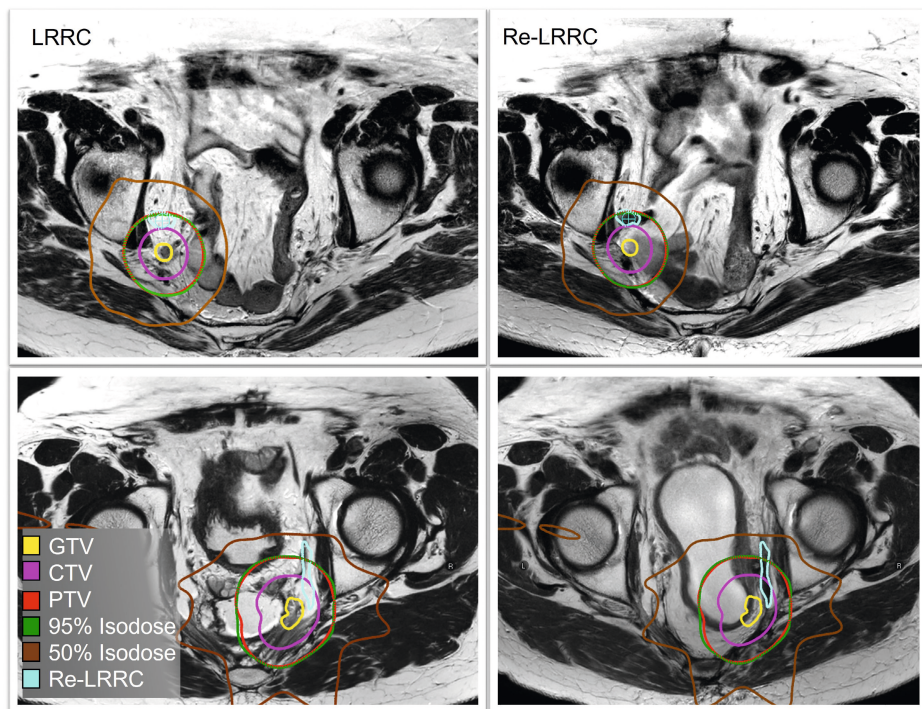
First (left) and second recurrence (right) shown on MRI of two individual cases (above and below). First and second recurrence MRIs have been matched to the LRRC planning CT, to be able to visualise the recurrence in the anatomy of the re-recurrence, and vice versa. The re-recurrence is shown in light blue. LRRC with target volumes (GTV yellow, CTV pink, PTV red) and isodose lines (95% green, 50% brown) are also shown. In both cases, re-recurrences developed in the lateral compartment, at the margins of the original PTV.
